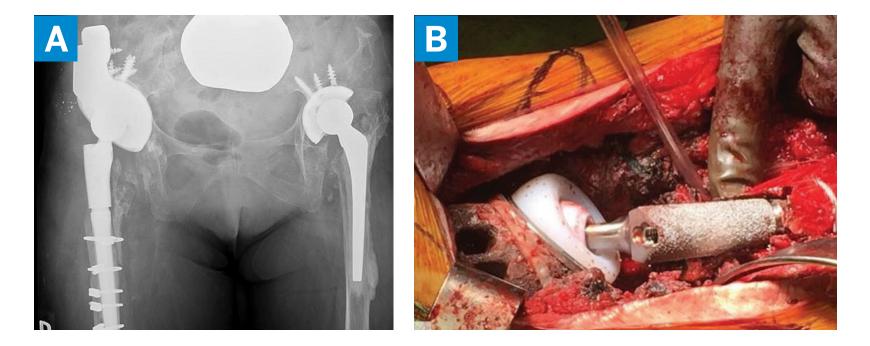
(A) Postoperative radiograph showing right hip reconstruction with an uncemented highly porous TM cup, superolateral TM acetabular augment, and long modular tapered uncemented stem. (B) Intraoperative photo showing dual mobility articulation.
